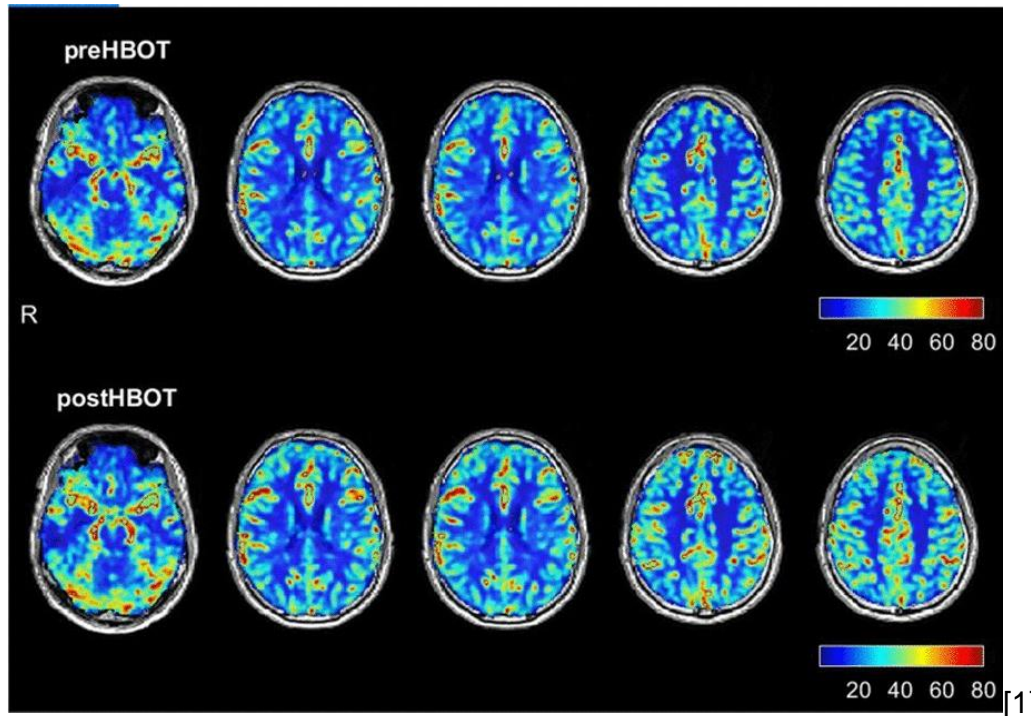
Brain perfusion magnetic resonance imaging before and after hyperbaric oxygen therapy. The upper row represents brain perfusion 3 months after the acute infection, before hyperbaric oxygen therapy. The lower row represents the perfusion magnetic resonance imaging done after completing the hyperbaric oxygen therapy protocol.
